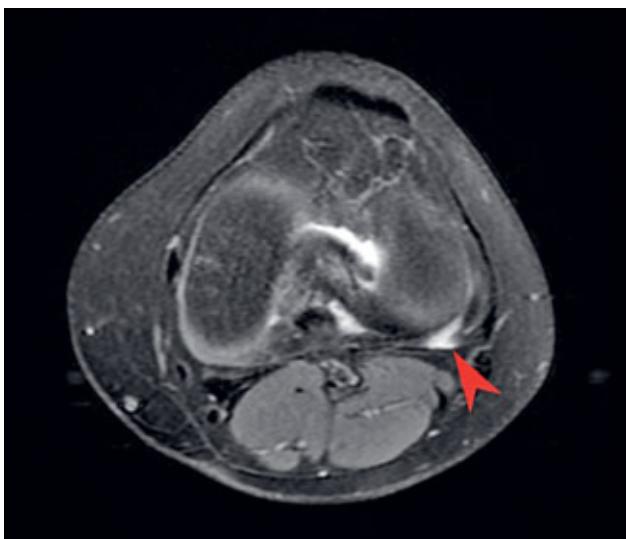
Pre-operative MRI, red arrow indicating hyperintense popliteus tendon.
